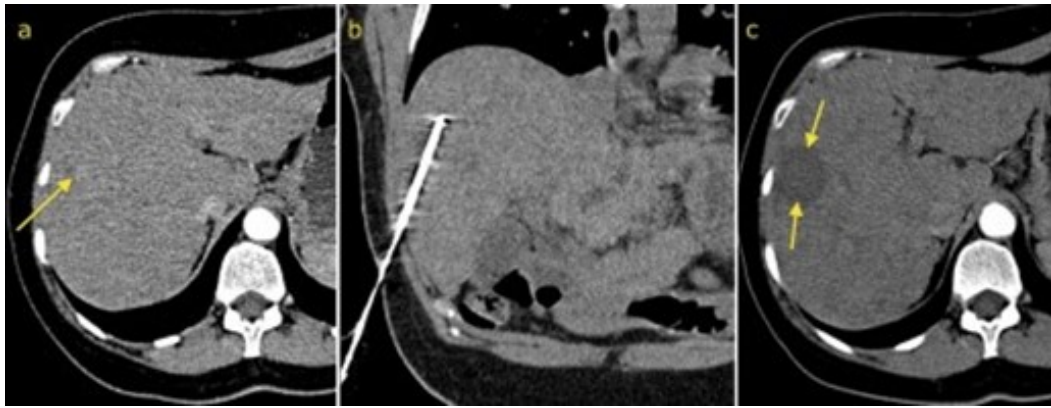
CT scans from before (a), during (b), and after (c) the ablation of a hepatocellular carcinoma. The ablated tissue is clear to see in (c) as the area of lower density. Reprinted from Radiology, St. Vincent's University Hospital at <http://www.svuhradiology.ie/case-study/radiofrequency-ablation-hcc/>, accessed in Nov 2018 [73].
